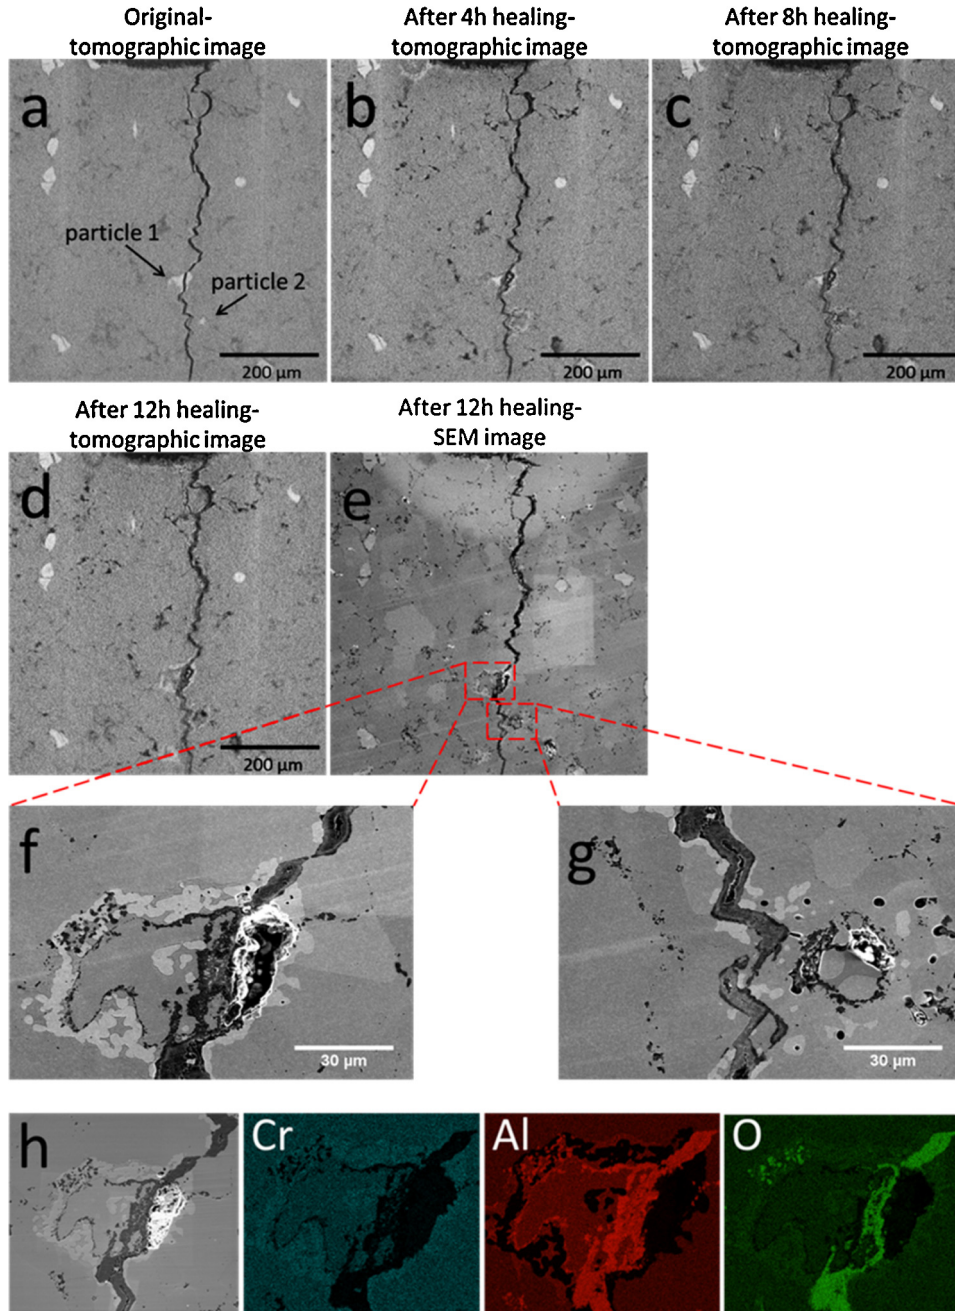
(a–d) Time lapse sequence of virtual X-ray tomographic slices of the same region-of-interest as a function of healing time (crack grew from top to bottom) at 1200°C in air. (e) Secondary electron SEM cross section of the same region-of-interest correlated to (d). (f–g) Higher magnification SEM images of the healed regions indicated by the red rectangles in (e). (h) EDS elemental maps of the region in (f). Particle 2 lies predominantly below the current virtual slice.
